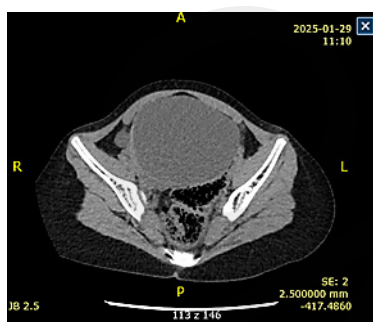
Computed tomography (Case 3)
